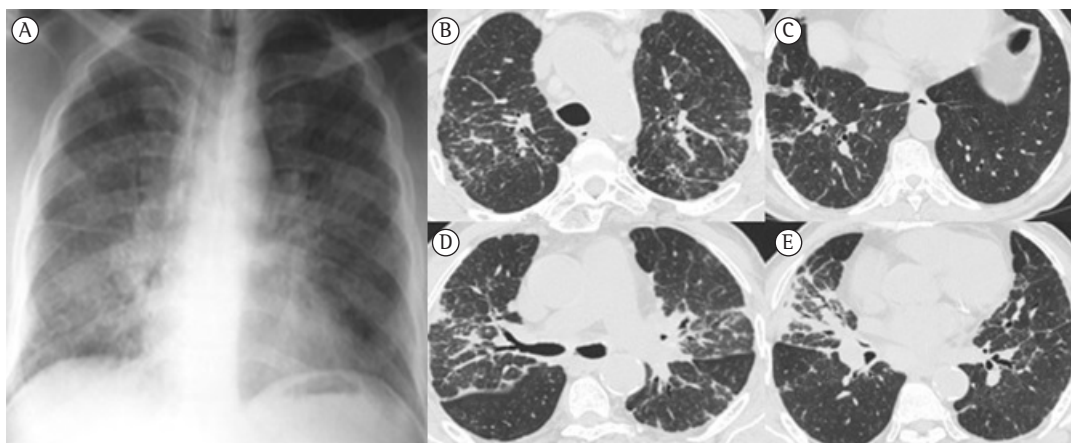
Initial radiological findings. In A, chest X-ray showing a reticular interstitial pattern predominantly in the lower lung fields, already denoting some loss of volume. In B-E, CT scan showing septal thickening patterns, traction bronchiectasis, small areas of ground-glass opacity, and consolidation with a peribronchovascular distribution.
